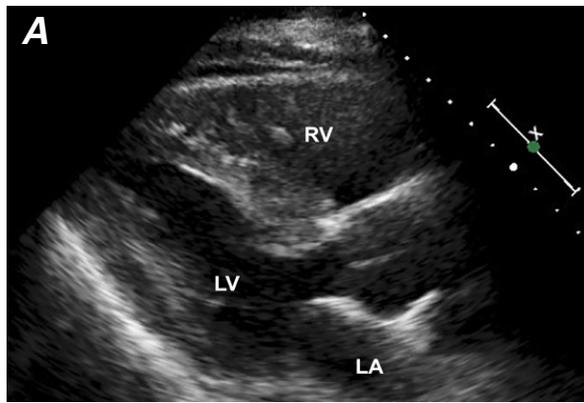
End-diastolic transthoracic echocardiograms. Parasternal long-axis views show A) mild right ventricular (RV) enlargement and a hyperdynamic left ventricle (LV) of relatively normal size on hospital day 3, and B) progressive RV enlargement and reduced LV size from interventricular septal shift and reduced LV filling on day 4. C) The end-diastolic apical 4-chamber view shows substantial RV enlargement and reduced LV size with hyperdynamic RV apical motion associated with hypokinesia of remaining segments (the McConnell sign).
